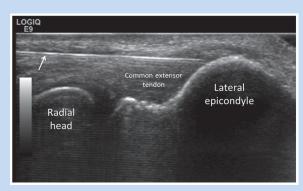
Ultrasound (US)-guided common extensor tendon fenestration in a patient with lateral epicondylitis. US image at the lateral elbow demonstrates a 25-gauge needle (arrow) within a thickened common extensor tendon for fenestration.
